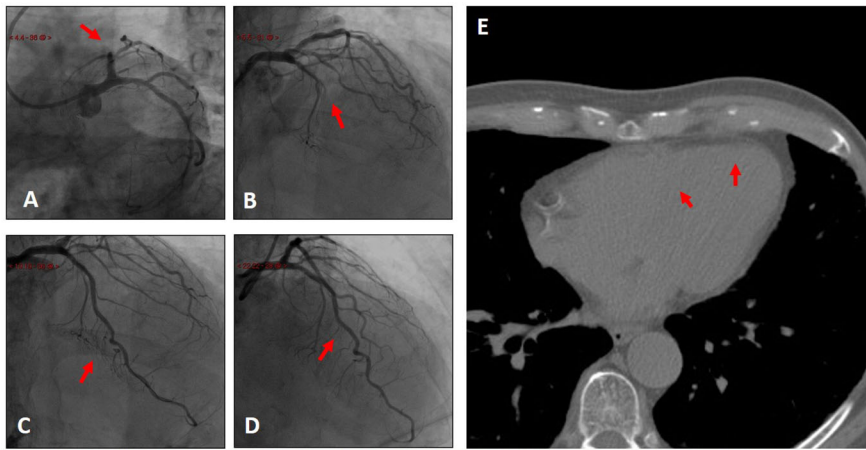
A 81-year-old man presented at the emergency department with an acute anteroseptal ST-segment-elevation myocardial infarction. Invasive coronary angiography (ICA) shows complete occlusion of LAD after first septal branch (arrow, A). A mid-LAD culprit plaque was demonstrated (arrow, B). LAD TIMI III flow was shown after mid LAD stenting (arrows, C and D). Noncontrast and nongated chest CT scan obtained 153 minutes after ICA shows no myocardial contrast retention suggesting complete myocardial reperfusion (arrows, D).
